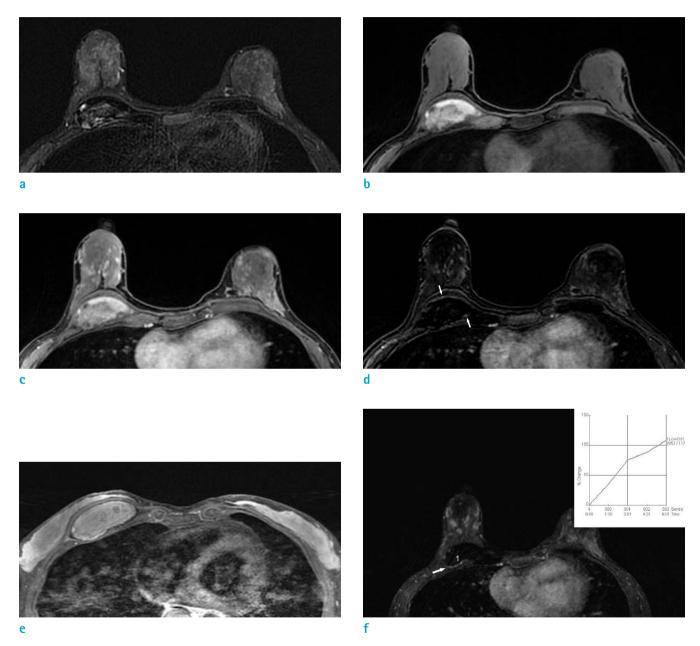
Dynamic breast MRI image using a 3.0-T scanner with intravenous contrast administration. (a) STIR image showing a dark intense lesion with multifocal high SI foci. (b) T1-weighted axial image showing a heterogeneous lesion with mainly high signal intensity compared to the pectoralis muscle. Low signal intensity rim was found for both signals. (c, d) Contrastenhanced fat suppressed T1-weighted image and subtraction image showing thin wall and a few tiny nodular enhancements at the peripheral portion of the mass (arrows). (e) Fat suppressed T1-weighted image using surface coil on supine position showing apparent thin low SI peripheral rim. (f) The kinetic curve of dynamic enhancement showing a persistent enhancement pattern.
